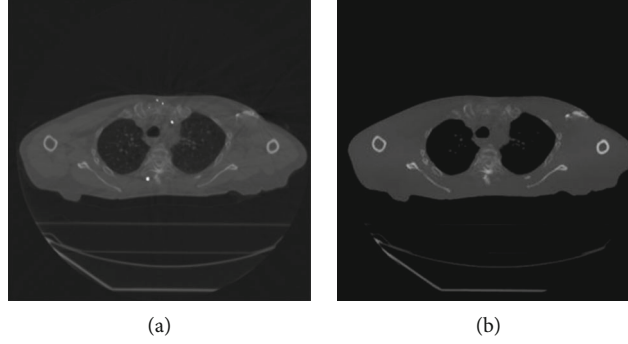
Corrected CT image and filtered CT image.
